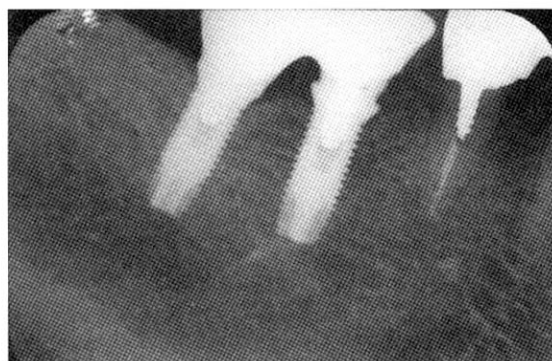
Periapical x-ray immediately after the delivery of final prosthesis
